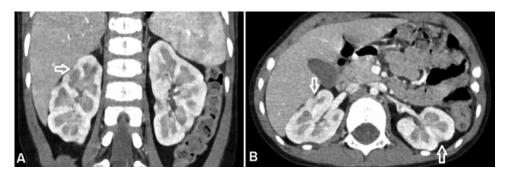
Abdominal computed tomography scans after 3 cycles of chemotherapy treatment. (A) Coronal and (B) axial images showed that the kidneys returned to normal size, the normal renal parenchyma enhanced strongly again, and the lymphoma-infiltrated areas became scars (arrows).
